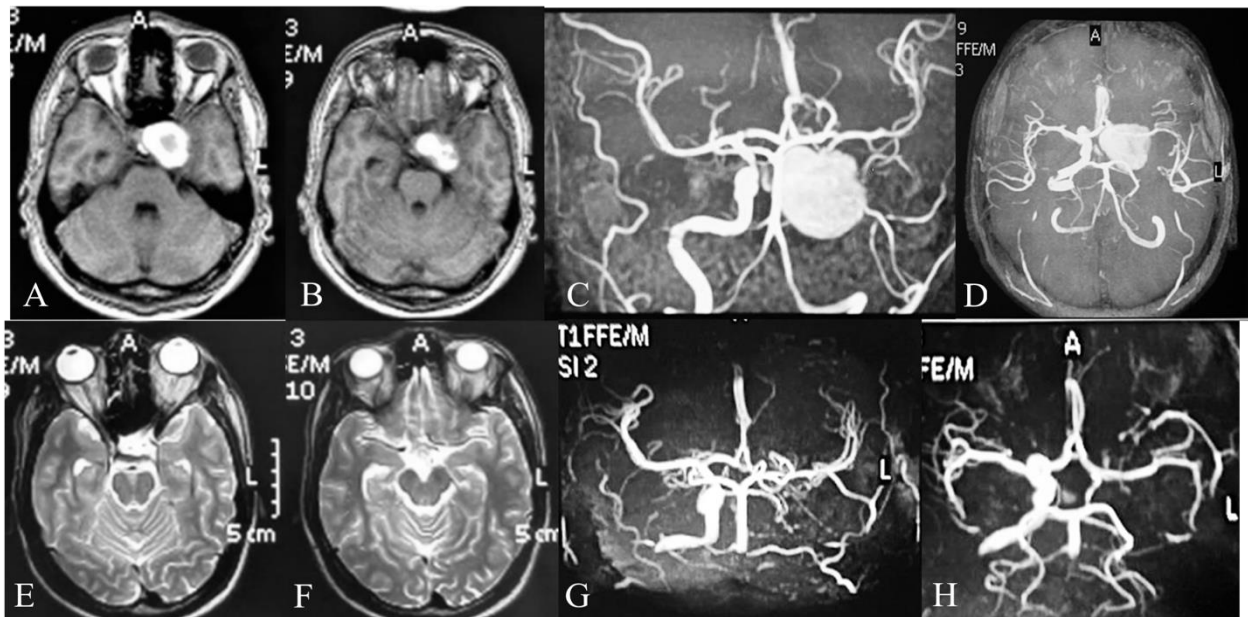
Brain MRI and MRA At presentation (A-D) showed a giant Left cavernous ICA aneurysm with mass effect on the left temporal lobe (A, B) with a striking shadow of the thrombosed aneurysm and absence of the left ICA proximal to the clinoidal segment in MRA (C, D). At 9-month follow-up (E-H) there is complete resolution of the aneurysm, no mass effect on the temporal lobe (E, F) with the disappearance of the aneurysmal shadow, and the same absence of the left ICA MRA (G, H).
